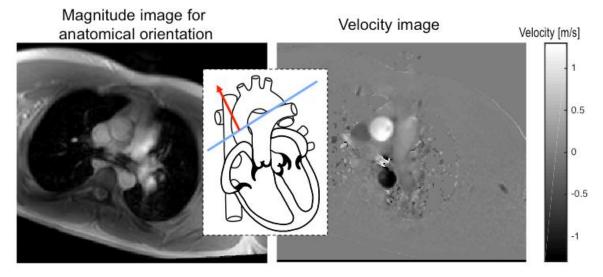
Data from a PC-MRI measurement of the ascending aorta at the location indicated in the middle. Left image: A so called magnitude image is obtained by displaying the magnitude of the complex PC-MRI signal. This image is used for anatomical orientation. Right image: A velocity image is obtained by exploiting that the argument of the complex PC-MRI signal is proportional to velocity. In this image the bright, positive velocity signal is seen in the ascending aorta where blood is moving towards the head. The dark, negative velocity signal is seen in the descending aorta where blood is moving towards the feet. Areas with stationary tissue such as the back and chest have zero velocity (gray in the velocity image).
